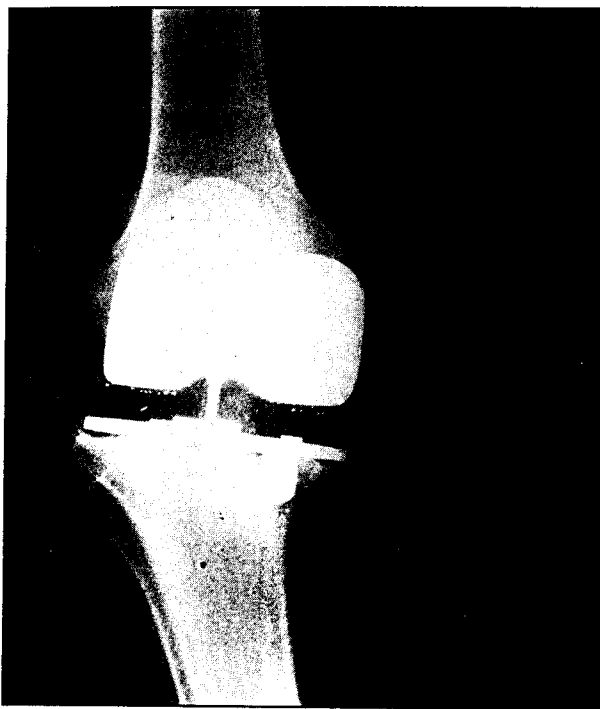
Radiograph of a cementless tibial component taken 47 months postsurgery showing medial subsidence with periprosthetic radiolucencies and evidence of loose beads.
